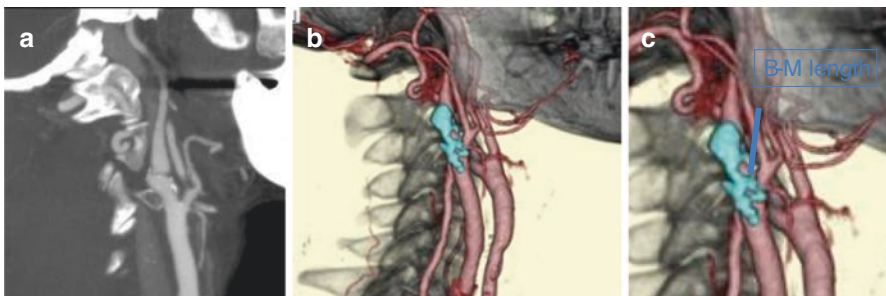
Computed Tomography Angiography (CTA) of carotid artery. (a) Maximum intensity projection (MIP) image. (b) 3D-CTA shows anatomical landmarks around the lesion. (c) Mandibular-Bifurcation length (M-B length) is useful to estimate the bifurcation point before CEA
